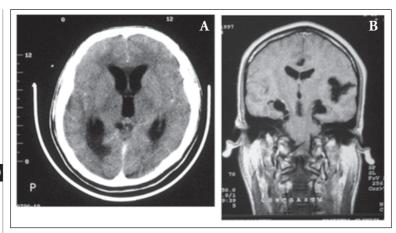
Neuroimaging findings in subarachnoid neurocysticercosis: A) CT showing hydrocephalus; and B) Contrast-enhanced CT showing subarachnoid cysts and abnormal enhancement of leptomeninges at the base of the brain.
